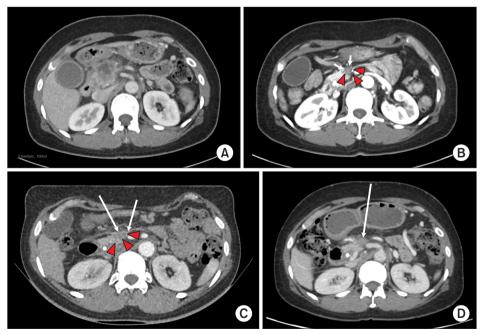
Pre- and post-treatment computed tomography (CT) images of the patient. (A) Initial CT image at diagnosis displaying an approximately 3 cm hypovascular mass in the pancreatic head, with superior mesenteric vein (SMV) invasion and superior mesenteric artery (SMA) abutment, indicating an unresectable status. (B) Post-mFOLFIRINOX chemotherapy CT image demonstrating a reduction in tumor size; however, the tumor remains unresectable due to persistent SMV invasion and SMA abutment. The mass in the pancreatic head is abutting the posterior wall of the stomach. (C) Post-omentopexy CT image displaying approximately 3 cm separation between the tumor and the stomach wall, achieved through spacer placement. (D) CT image 1 month after carbon-ion radiotherapy, demonstrating a stable disease with no significant abnormalities in adjacent
